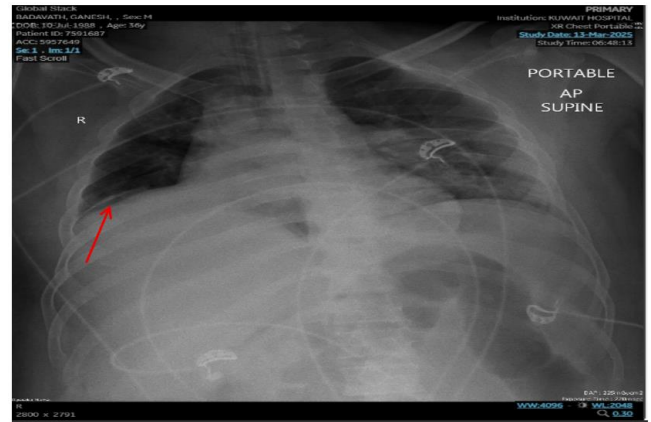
Chest X-ray revealing pleural effusion (Arrow A) and accentuated bronchovascular markings (Arrow B)
